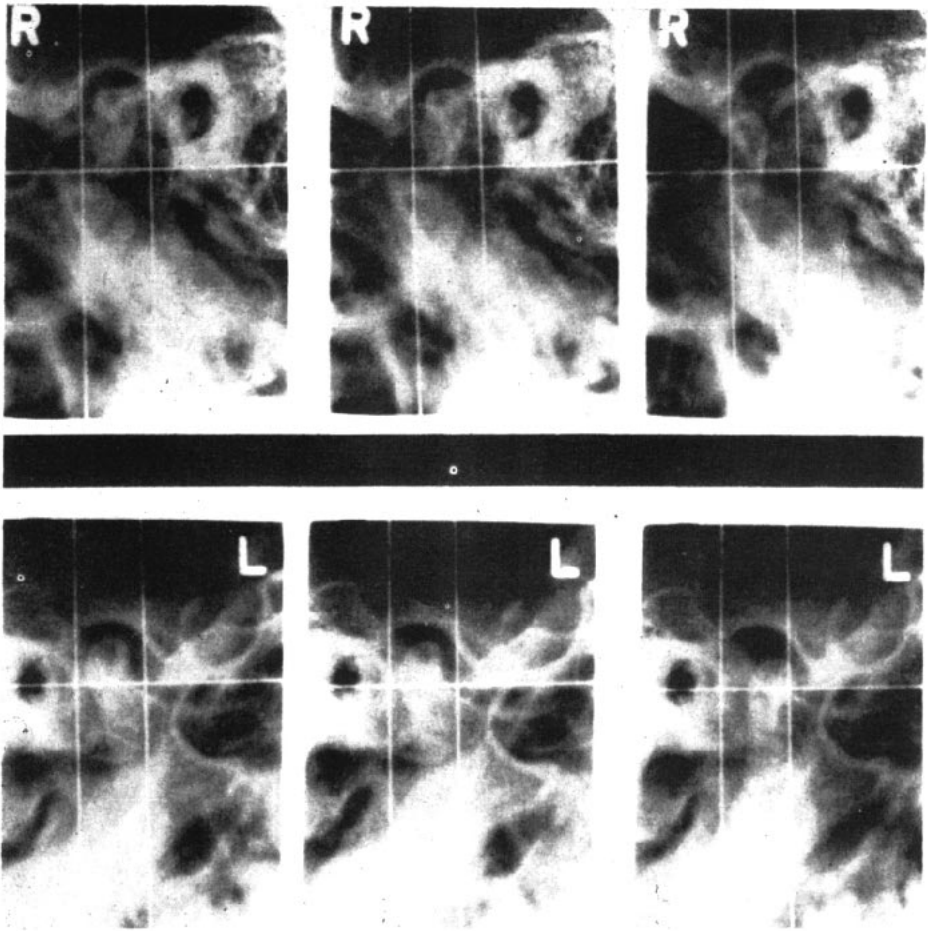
Radiographs demonstrating the use of orientation rods which aid in checking condylar movements and condylar-fossa relationships.
